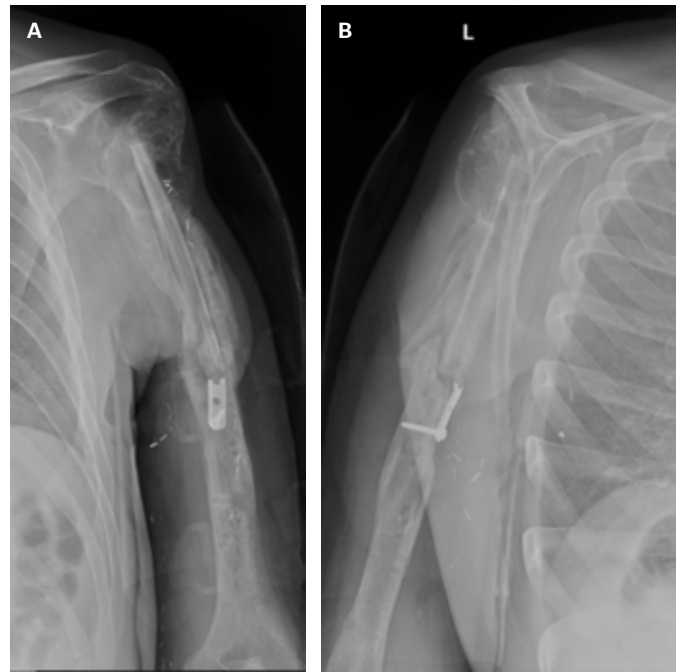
Left humerus x-rays from most recent follow up visit. (A) AP and (B) lateral showing evidence of vascularized bone graft in the proximal femur. The bridge plate has been removed. Fracture lines are still present but there is slightly more callus along the course of the humeral shaft compared to prior imaging. Glenohumeral arthritis is noted.
